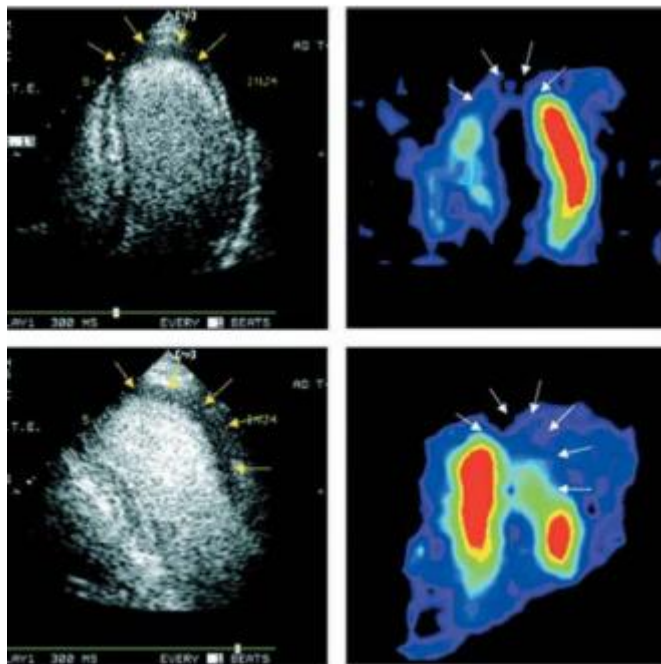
Myocardial Contrast Echocardiography (MCE) (left column) and corresponding SPECT images of a patient having anterior myocardial infarction [30].
